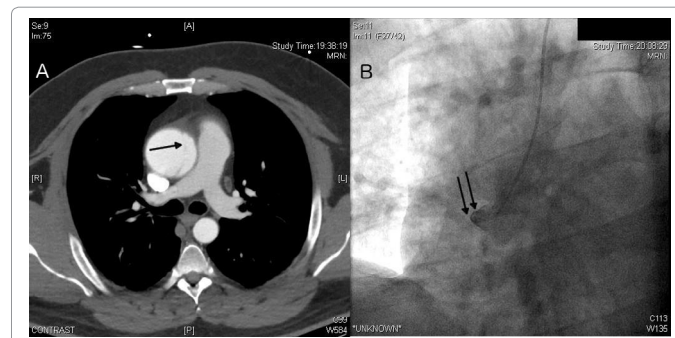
a) Preoperative CT-scan shows the dissection membrane in the ascending aorta (arrow). b) preoperative angiography with proximal closure of the right coronary artery (double arrow).
